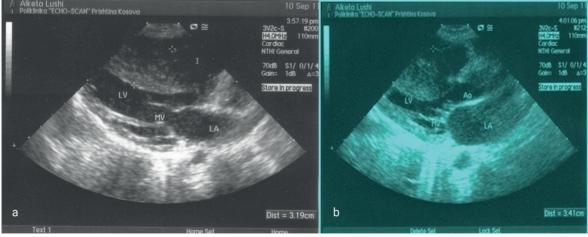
Parasternal left ventricular long-axis echocardiografic section obtained a patient in diastole (a) and systole (b) with hypertrophic cardiomyopathy.
